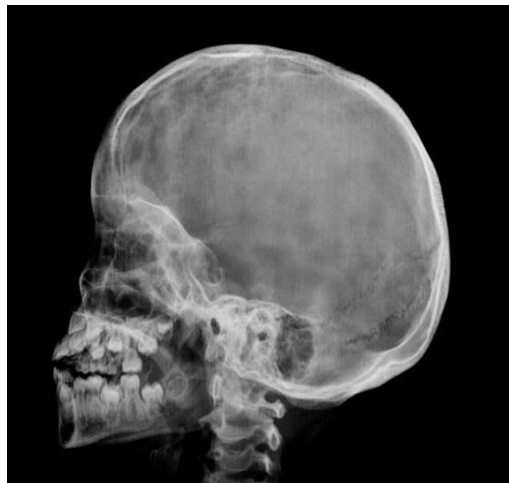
Lytic lesion on skull and mandibular bone esion in expansion in skull radiograph.
